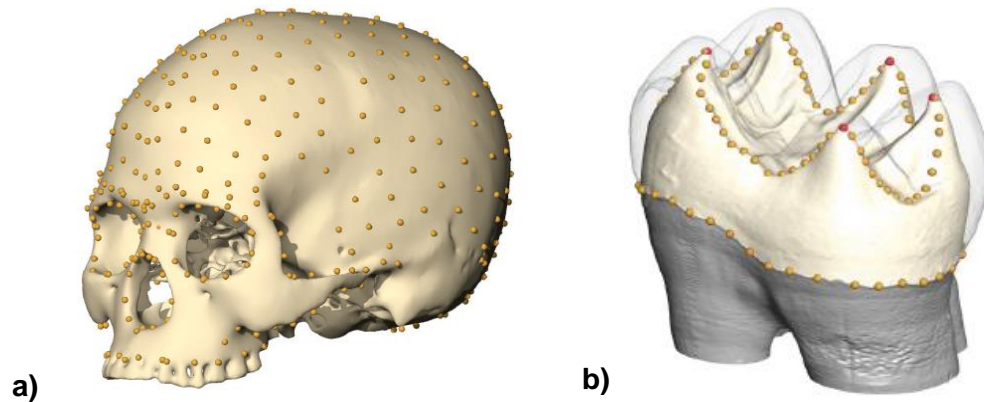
Landmarks and semi-landmarks positioned on the surface of 3D computed tomography (CT) scans of a) a human skull and b) a human tooth (189).
